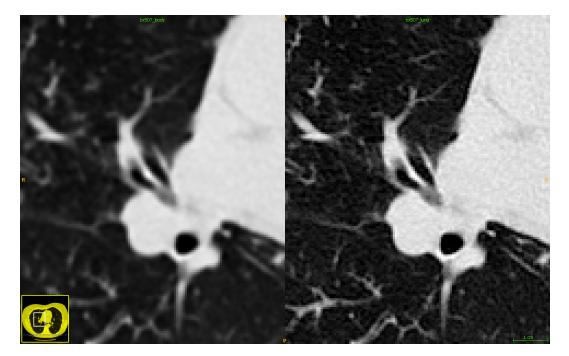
Images from the same CT scan with the body kernel (LEFT) and lung kernel (RIGHT). Both images are displayed in the same intensity window.
